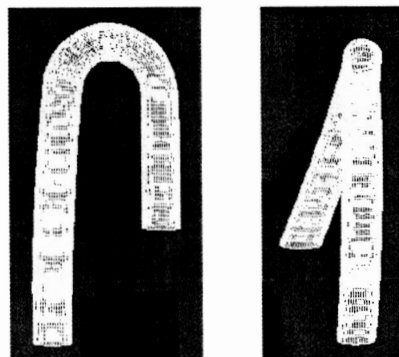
MRI-based reconstructed geometry of the non-planar aortic arch model
